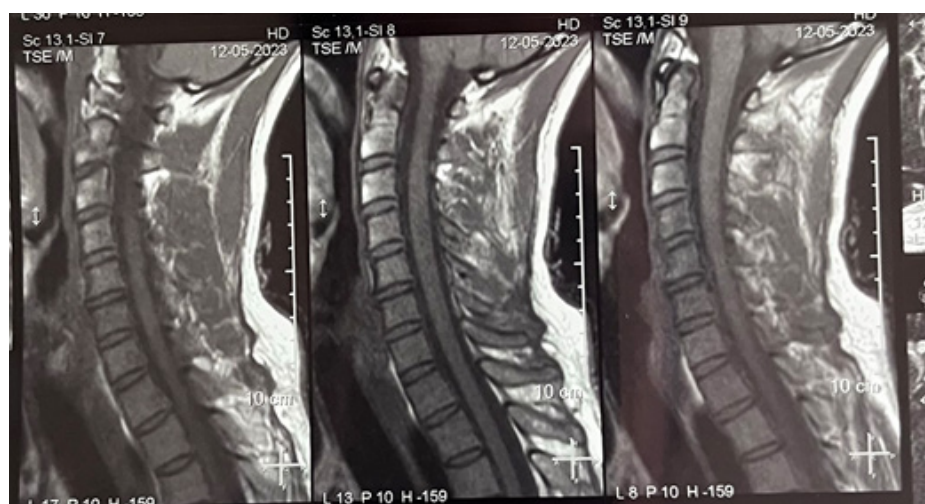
MRI of the spine.
